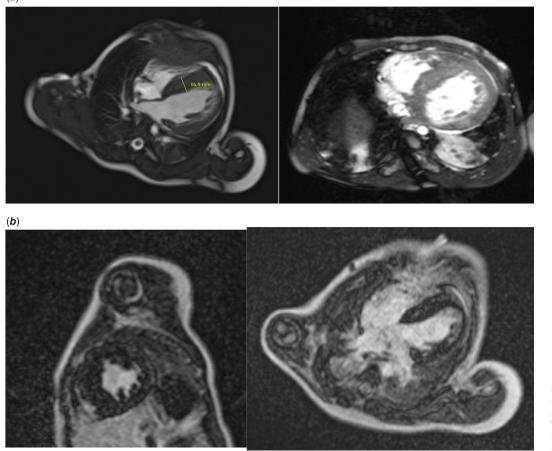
Cardiac MRI images significant for severe septal hypertrophy and increased trabeculation. The For Peer Review interventricular septum measures up to 16.9 mm.
